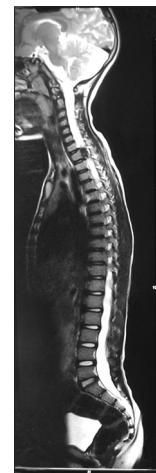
Magnetic resonance imaging of the whole spine revealed an enhancing extradural mass protruding into the spinal canal at T1 vertebral level
